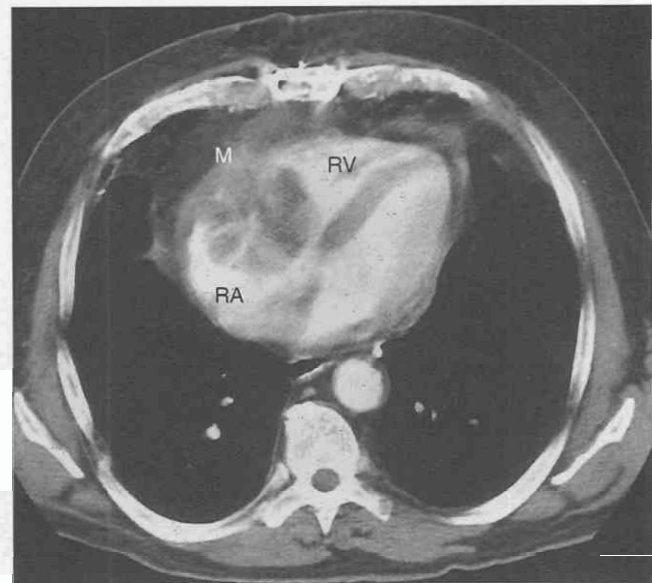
Primary cardiac lymphoma in a 42-year-old man. Contrast-enhanced CT following open biopsy shows a lobulated mass (M) within the right heart at the level of the tricuspid valve. The mass extends into the right atrial and right ventricular cavities. Open surgical biopsy confirmed the tumor involvement of the tricuspid valve, right atrium, and right ventricle. RA, right atrium; RV, right ventricle.
